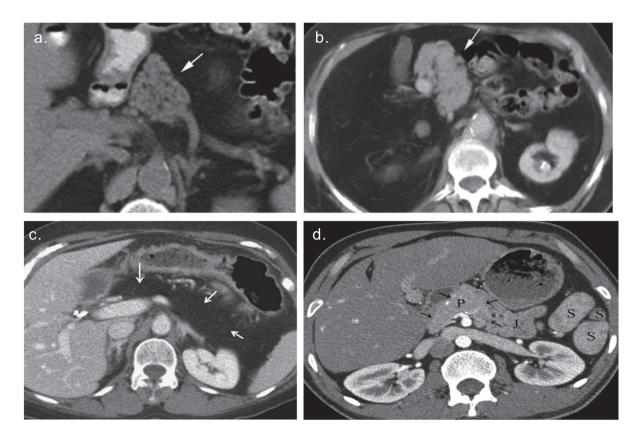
Pancreatic hypoplasia, CT scans. a. Absence of the pancreatic neck, body and tail with presence only of the pancreatic head (arrow). b. A truncated midline pancreas in a patient with heterotaxy syndrome. [Mortelé, K.J., Multimodality Imaging of Pancreatic and Biliary Congenital Anomalies] c. Fatty infiltration of the pancreatic body and tail. [Alexander L. Congenital Pancreatic Anomalies, Variants and Conditions] d. Partial dorsal agenesis of pancreas (arrows) in patient with polysplenia syndrome; small bowel loops seen in the dorsal pancreatic bed. P: pancreas, J: jejunum, S: spleen. [Türkvatan A., Congenital Variants and Anomalies of the Pancreatic Duct]
